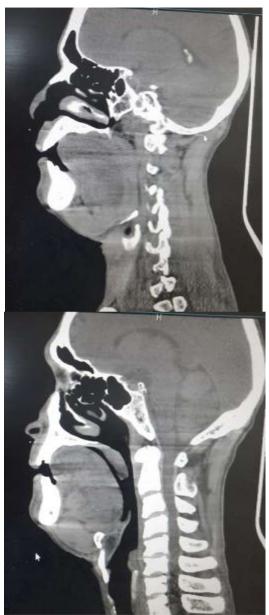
Sagittal sections of CT Neck (plain) showing the bulky tongue with suspicious amyloid deposits.
